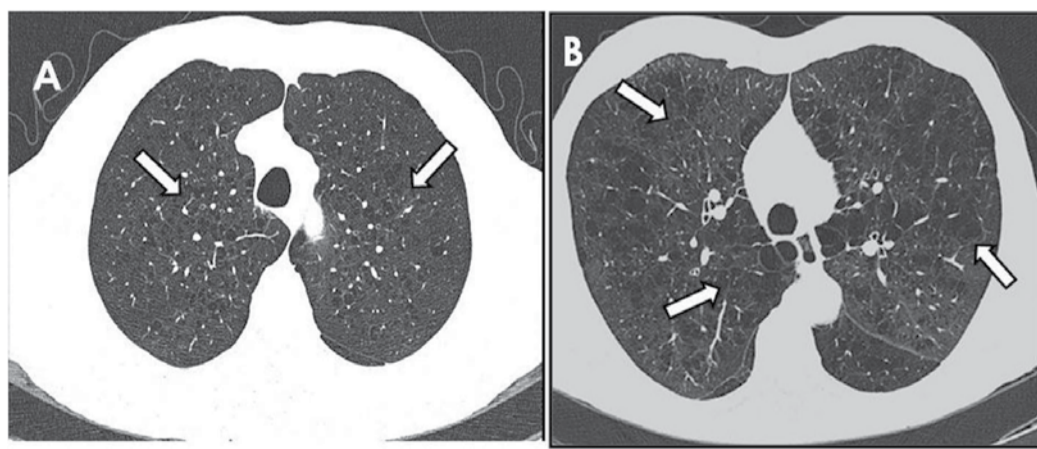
a and b show high resolution computed tomography of two different respiratory asymptomatic individuals with different severity of emphysematous lesions (arrows) (From: Buedia-Roldan I, et al. BMC Pulm Med. 2020).
